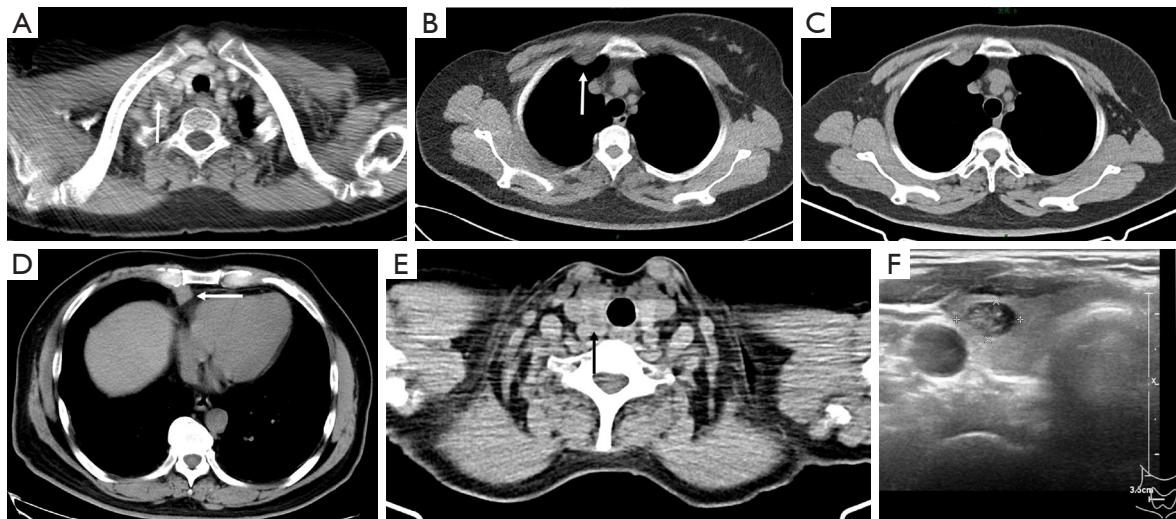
Blind spots on chest CT: external mediastinal lymph nodes and thyroid. Lymph nodes located outside the mediastinal area on chest CT, such as (A) those above the right clavicle (arrow) and (B,C) those in the internal mammary region (arrow), may be easily missed. (D) A 65-year-old male after surgery for a thymoma. During the follow-up period, a tumor nodule in the right cardiophrenic angle region (arrow) was missed and later confirmed as a thymoma recurrence (type AB). (E,F) A 64-year-old female with an incidentally detected low-density nodule in the right thyroid lobe (arrow) during low-dose CT screening; this nodule was identified as a nodular thyroid goiter through ultrasound. CT, computed tomography.
